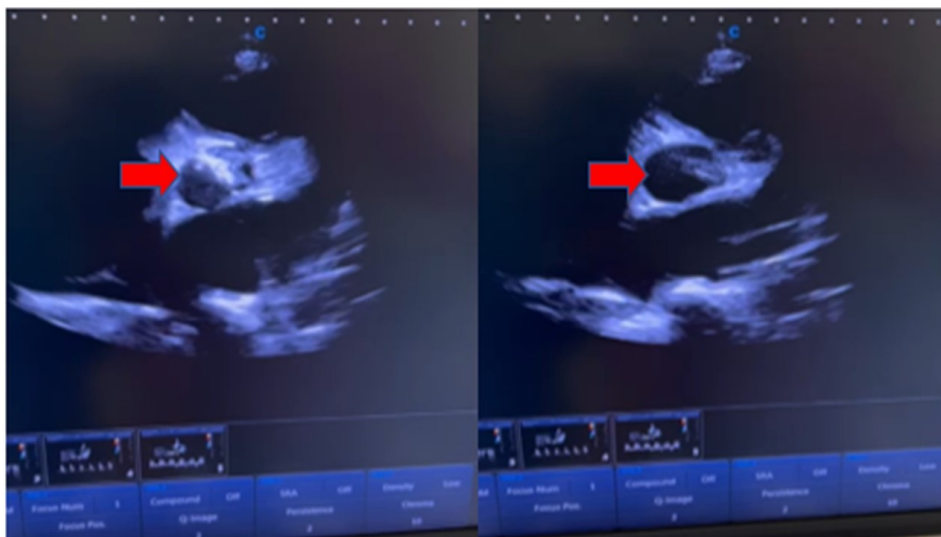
Echocardiography examination showing bicuspid aortic valve (red arrow).
